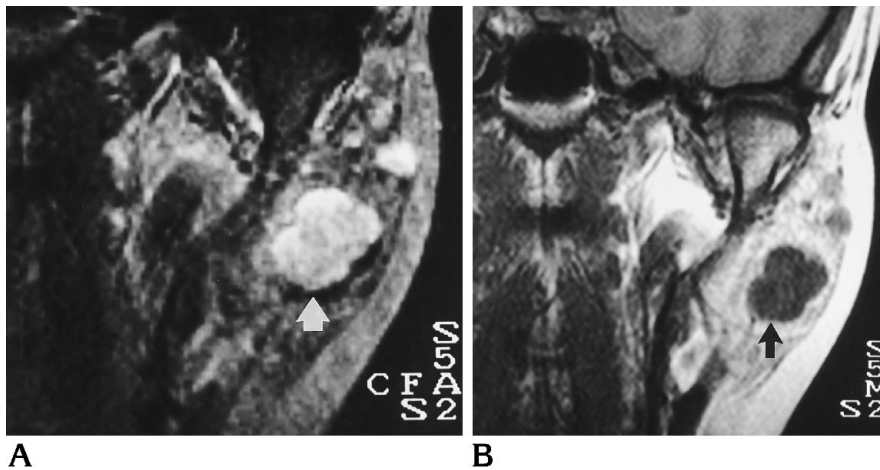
Pleomorphic adenoma in the superficial lobe of the left parotid gland. Coronal T2-weighted (2000/80) (A) and T1-weighted (500/20) (B) MR images show that the tumor has well-defined margins (arrows) and a lobulated contour. The lobules are about 1 cm in size.
